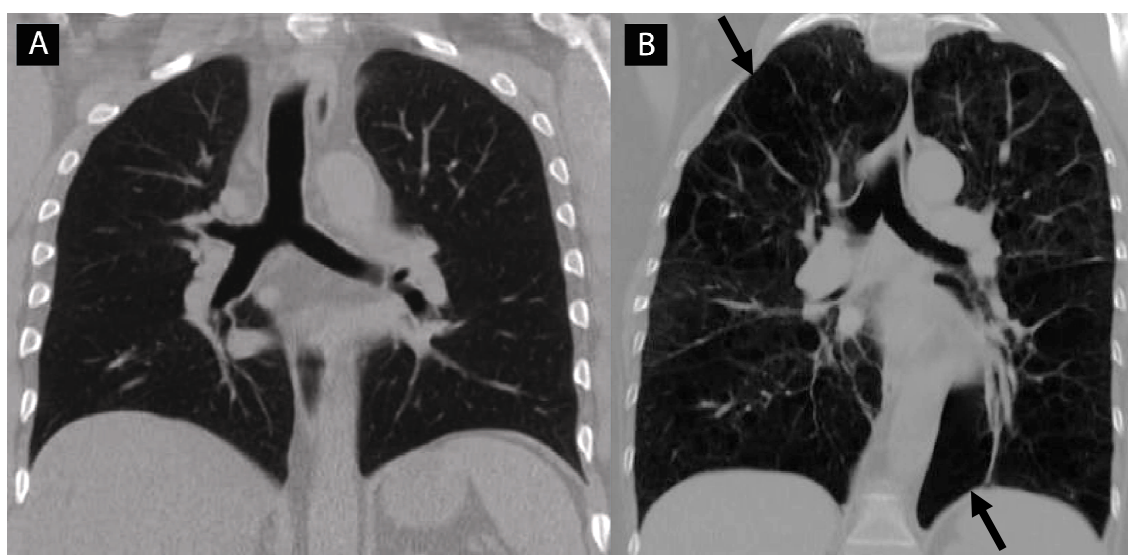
X-ray computed tomography (CT)
